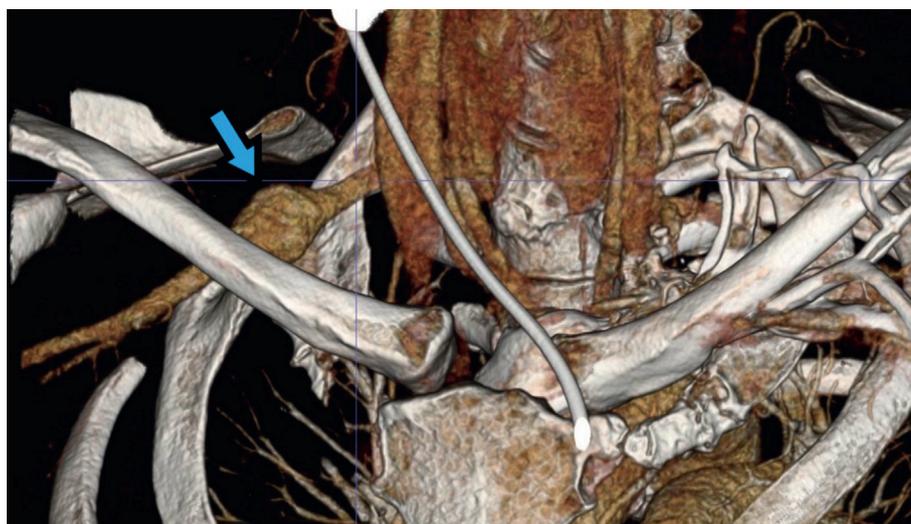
A CT angiogram with 3D reconstruction showing a cervical rib and its relationship to the broad and flat first rib below.
